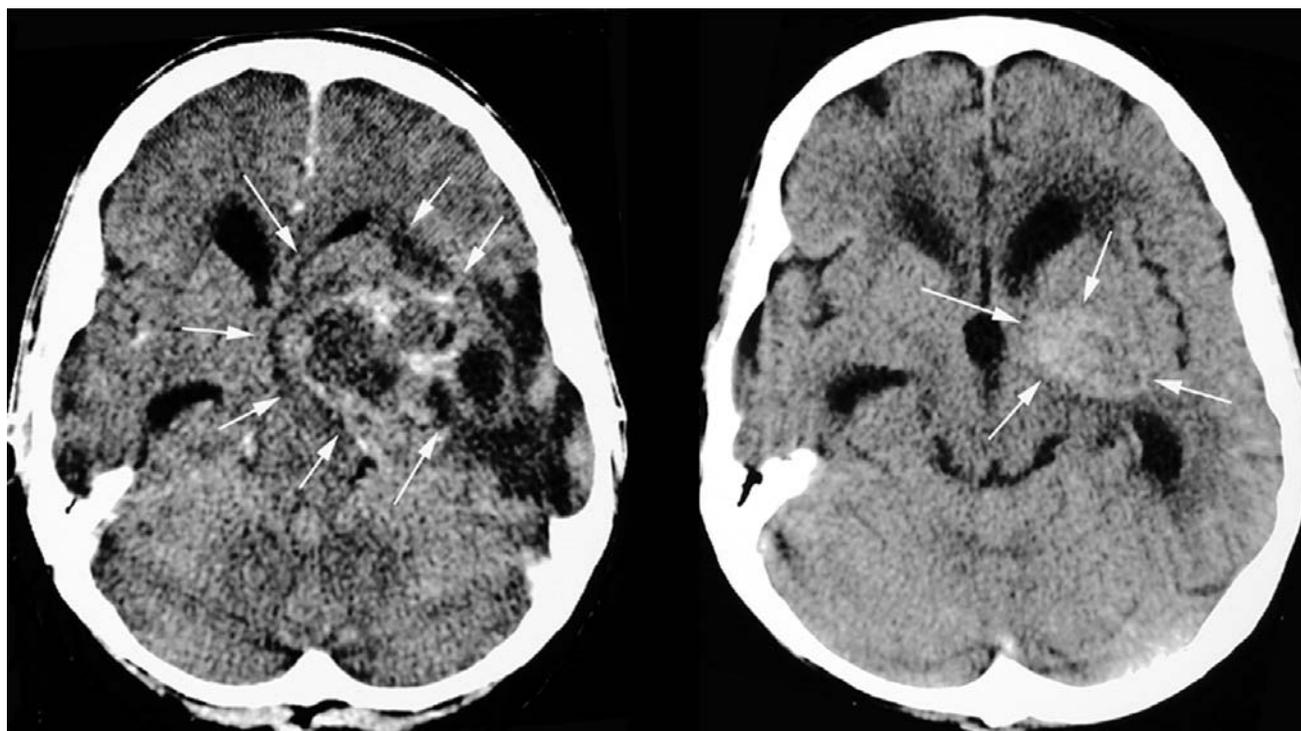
CT scans obtained following radiochemotherapy prior to the taurolidine treatment (left) demonstrate a large left temporal glioblastoma with cystic components and marked perifocal edema. Note the ventricular compression and midline shift. CT with contrast medium scans following taurolidine treatment (right). Marked regression of the solid and cystic tumor components and disappearance of the perifocal edema.
